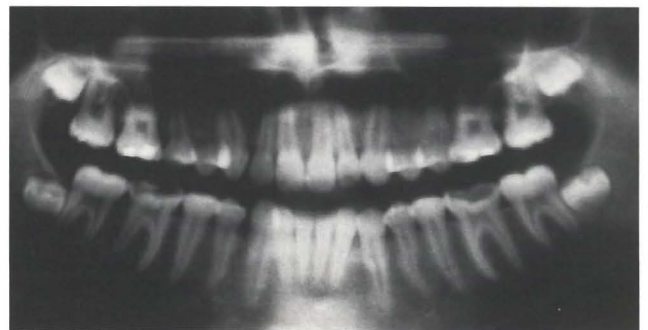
Panoramic radiograph in five years postoperative with the osteal recovery and radicular formation complete of the permanent teeth involved in the lesion.
